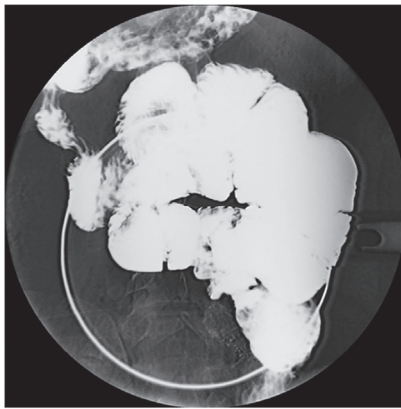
Barium meal follow through radiograph shows small bowel loops bunched and confined in the central abdomen and with a cauliflower sign. The clustered bowel loops maintain a constant position when pressed.
